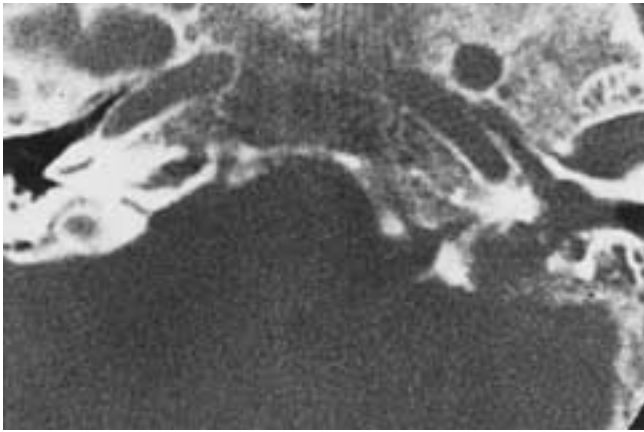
Anaplastic carcinoma of the jugular foramen. CT. Irregular, ill-defined destruction of the left jugular fossa is indistinguishable from that of glomus jugulare tumor. A selective external carotid angiogram (not shown) showed no tumor vascularity.
